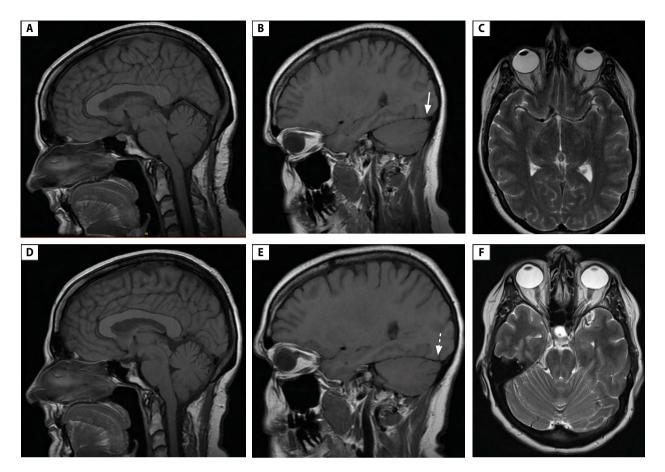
A patient with new daily persistent headache for 30 years was found to have spontaneous intracranial hypotension from a multilevel, ventral, upper thoracic spine, longitudinal epidural fluid collection. There was a history of posterior fossa decompression for a (questionable) Chiari 1 malformation diagnosis 18 years prior to leak discovery. Patient underwent CT-guided fibrin patching to ventral upper thoracic spine 10 months after pre-treatment images (A, B, C) were taken, which show classic stigmata of intracranial hypovolemia. A: engorged pituitary gland and mild brain sag; B: right optic nerve is straight in vertical plane (normal); right transverse venous sinus is engorged (solid arrow); C: optic nerves are straight in horizontal plane (normal). Patient developed a headache pattern change and papilloedema with perinerve haemorrhage within three weeks of patch. Post-treatment images (D, E, F) were taken six weeks after treatment, demonstrating new stigmata of intracranial hypertension. D: partially empty sella turcica; E: subtle tortuosity of right optic nerve in vertical plane (abnormal), and development of right transverse sinus stenosis (dashed arrow). F: bilateral horizontal optic nerve tortuosity (abnormal). Patient ultimately required ventriculoperitoneal shunting for persistent intracranial hypertension despite high-dose oral acetazolamide therapy
